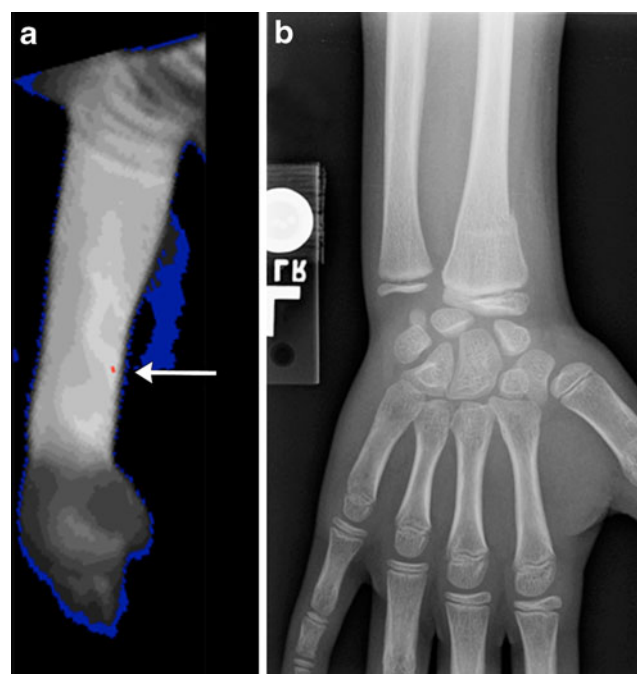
Ten-year-old girl who fell from self-height. a The forearm was considered the warmest segment on DITI (*arrow*), which was obtained 18 h after the trauma. b The wrist was considered as positive for fracture on the radiograph. DITI was considered to match the site of injury
